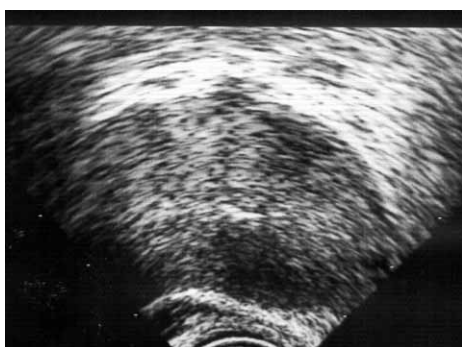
Transrectal sonography showing two hypoechoic prostate cancer lesions in the left prostatic lobe
